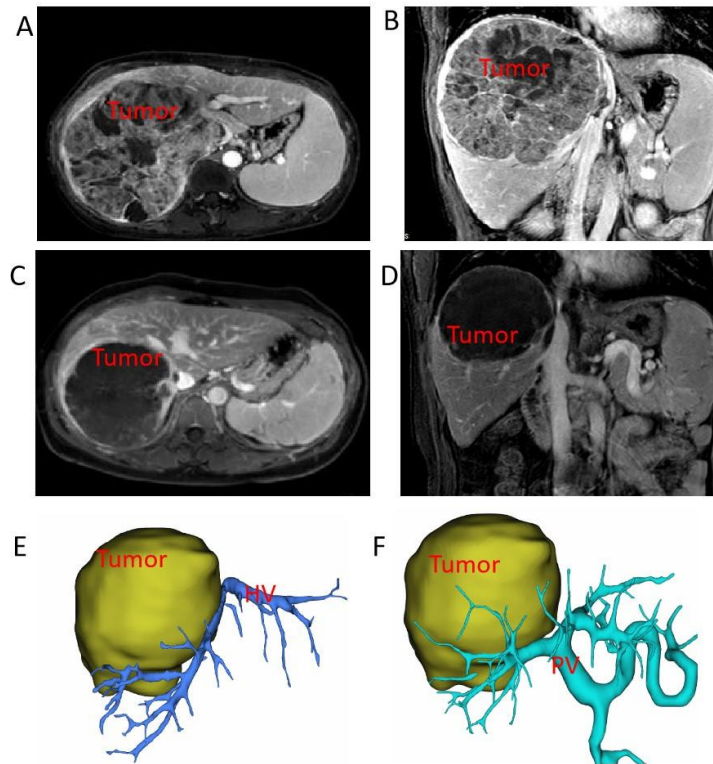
Comparison of MIR before and after conversion therapy. MRI images at the first visit showed that the tumor volume was large and the enhancement in arterial phase was obvious (A, B); MRI image before operation showed that the tumor was obviously liquefied and necrotic, and the inferior vena cava tumor thrombus had no arterial phase enhancement (C, D); preoperative 3D reconstruction to clarify the relationship between tumor and portal vein and hepatic vein (E, F).
